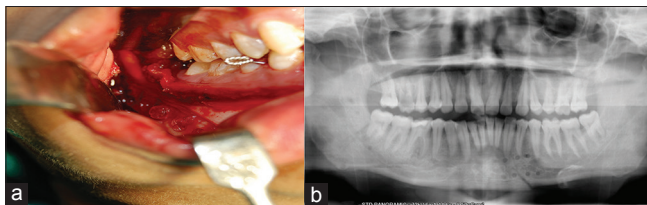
(a) Bioresorbable plate applied at the angle fracture; (b) postoperative orthopantomogram showing reduction and fixation, as evidenced by drill-holes across the fracture lines
